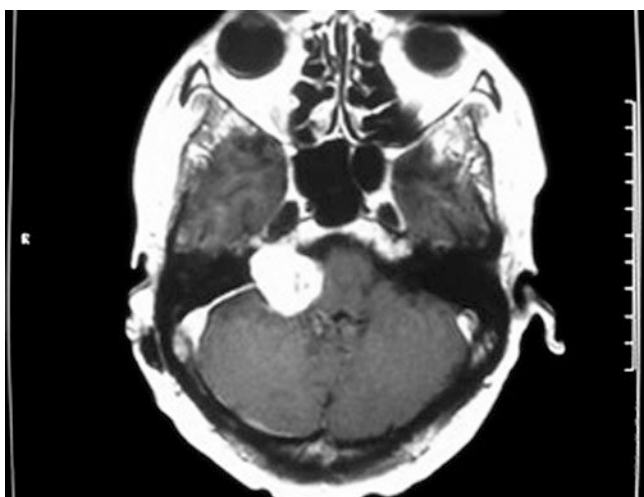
Left hemifacial spasm patients, preoperative MRI showed left acoustic neuroma
